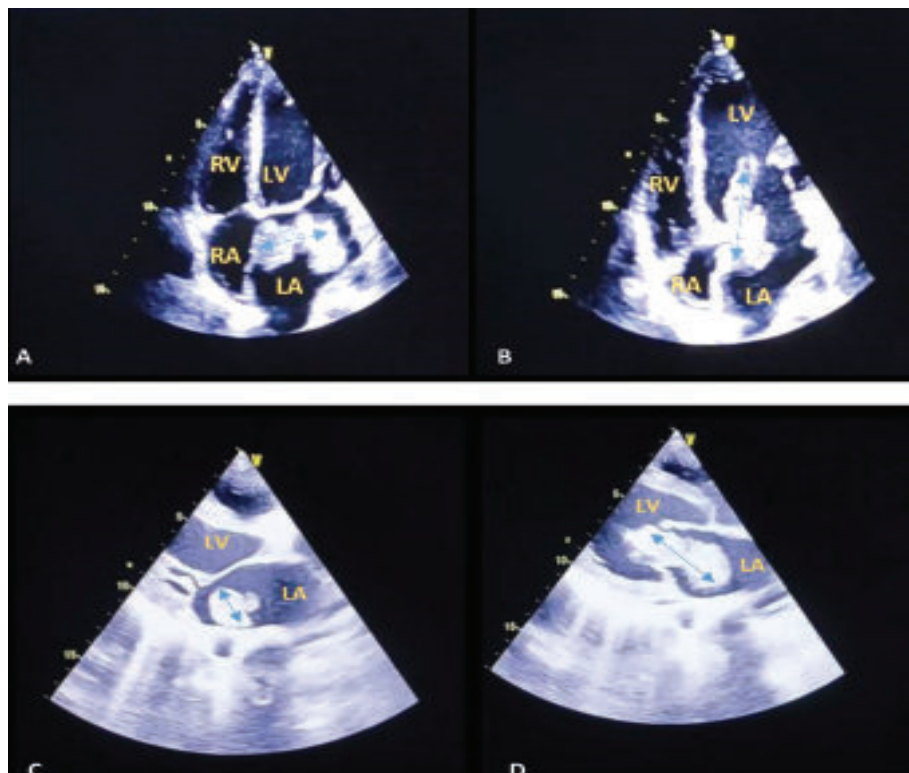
Showing 2D M-mode echo (A: Apical view, B: Parasternal long axis view) showing an atrial myxoma (65 x 23 mm in size) which protrudes towards left ventricle through the mitral valve during diastole. LA, LV was dilated. Biventricular function was normal with no RWMA.
